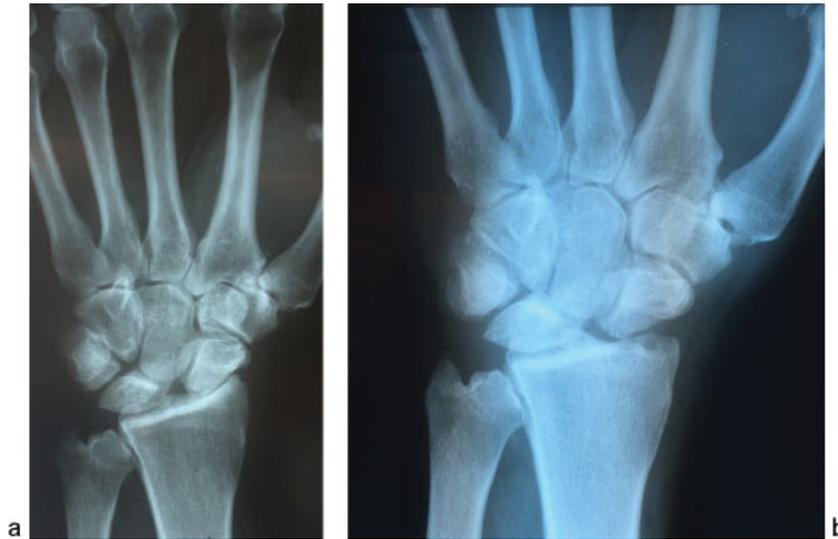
(a) Preoperative radiograph of 46-year-old male showing radiographic stage 2+ (patient ID #6). (b) Postoperative PA radiographic at 2 years following an arthroscopic resection arthroplasty of the radial column with excellent clinical outcomes that resulted in 0/10 pain and 5/5 satisfaction (patient ID #6).
